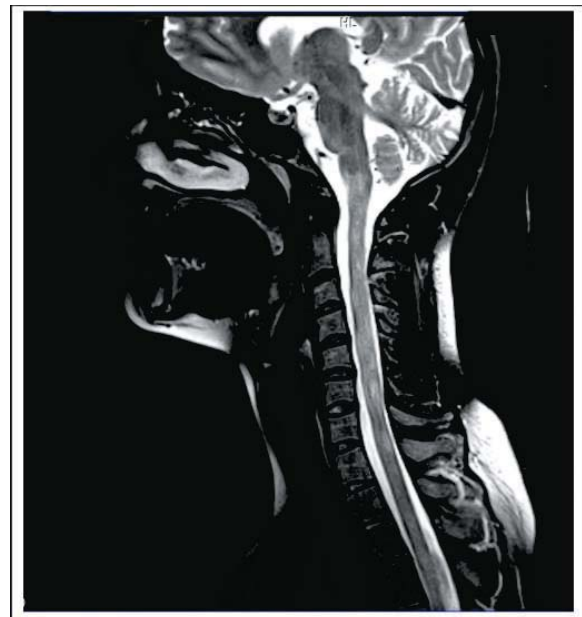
Spinal cord MRI scan showed multiple demyelinating lesions in acute phase
